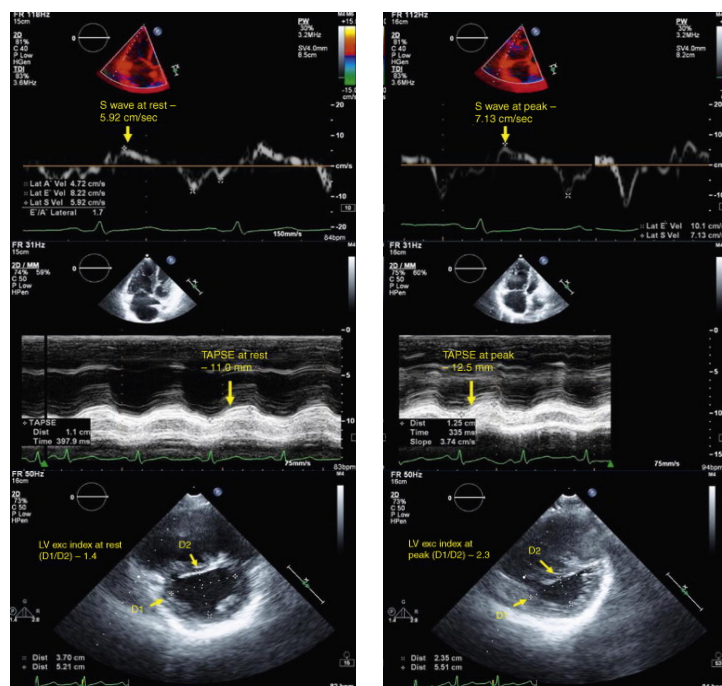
Echocardiographic assessment of RVCreserve of a pulmonary hypertension patient at rest (left) and on exercise (right). i) S wave velocity, ii) TAPSE, and iii) LV eccentricity index (EI). Note increases in S' wave velocity and TAPSE on exercise with a deterioration in EI with flattening of the interventricular septum indicating RV pressure/volume overload. Adapted from Aleida et al.[39]
